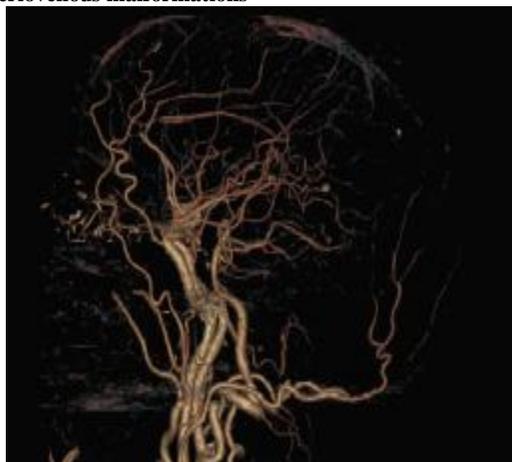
Cerebral Angio-CT scan - Lack of arteriovenous malformations
